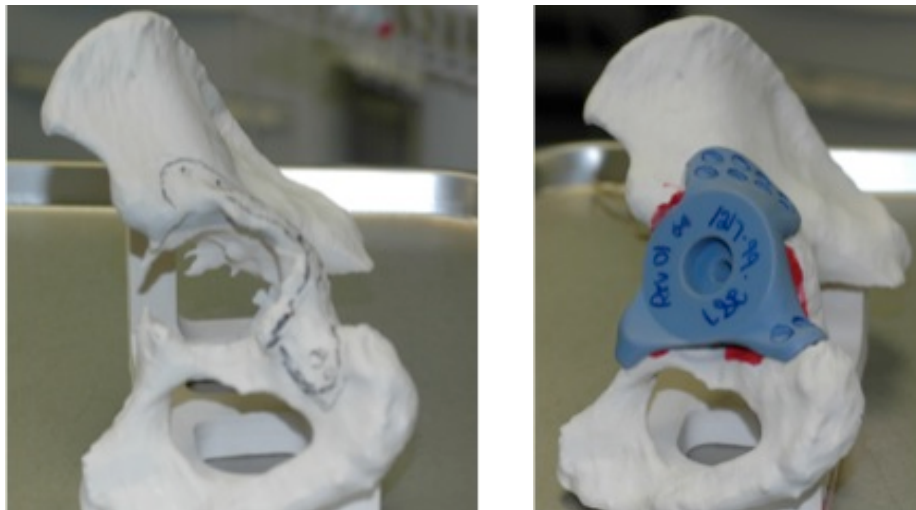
Acetabular Model and model of custom designed cup, made from CT scan of deficient acetabulum. Flanges are designed to anchor to the ilium and ischium with screws.
